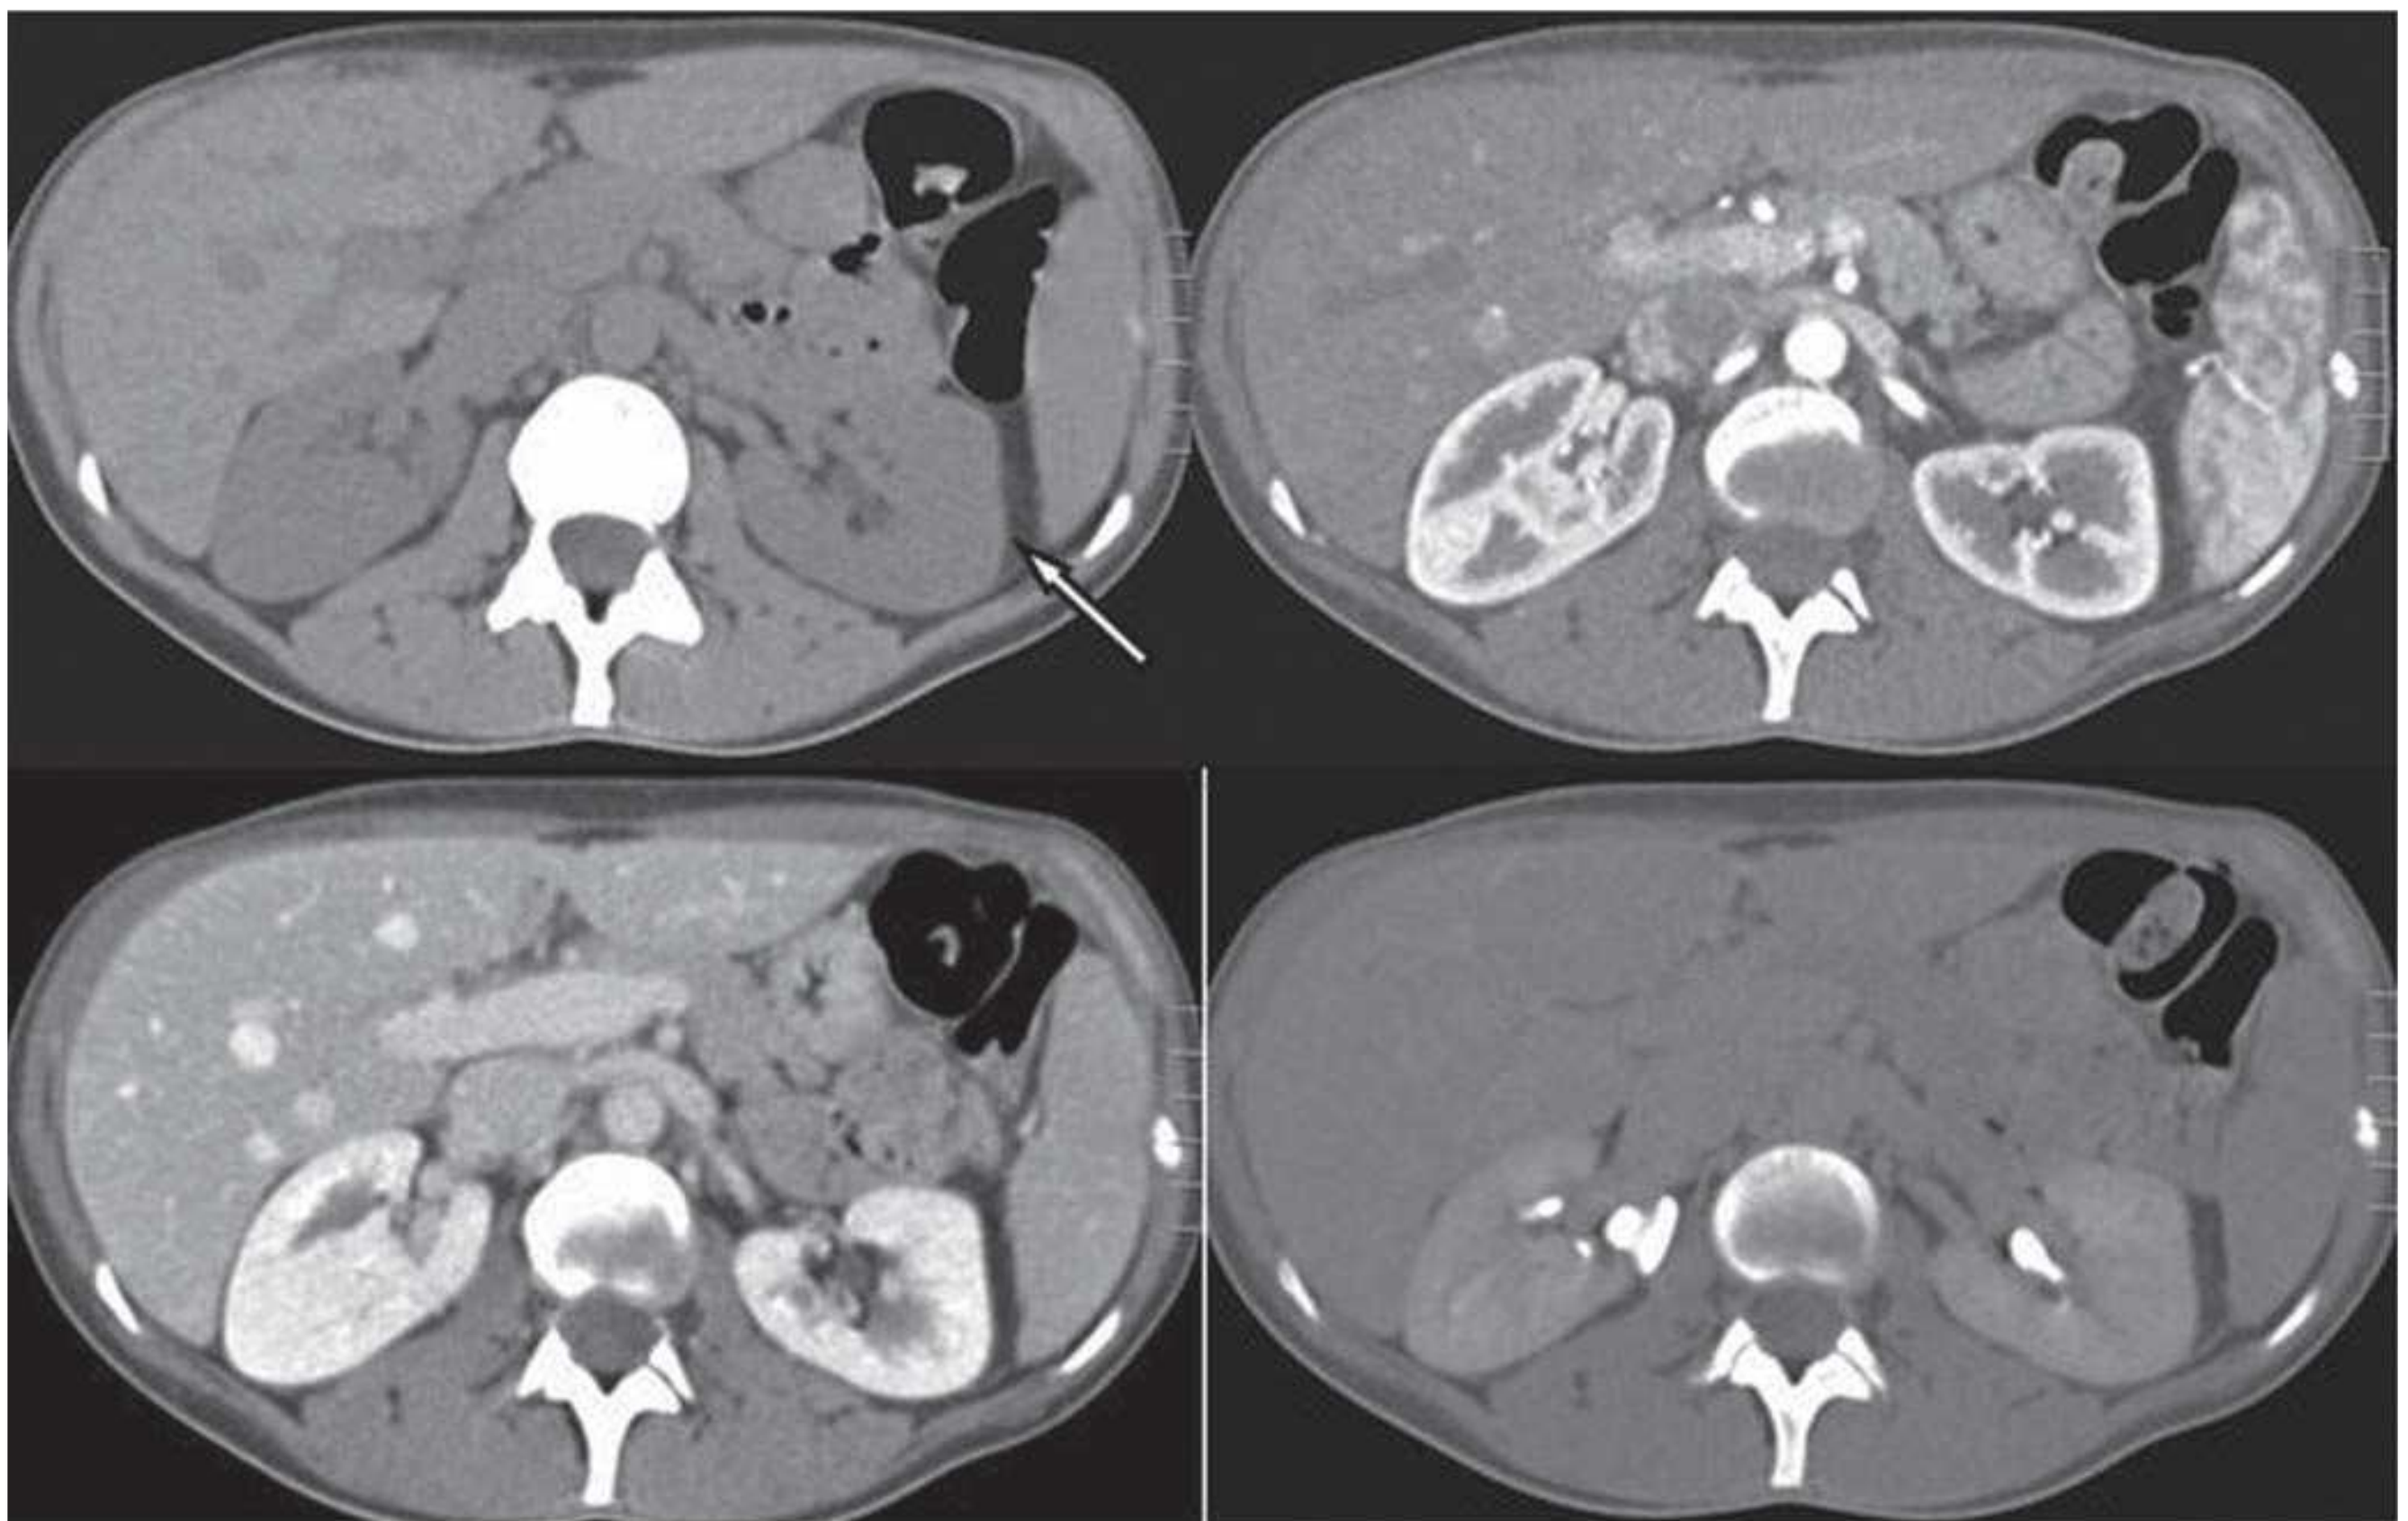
CT images of normal kidneys obtained without intravenous contrast (*left upper*), at corticomedullary phase with contrast (*right upper*), nephrographic phase (*left lower*), and delayed excretory phase (*right lower*). The arrow points to the peri-renal fat.
